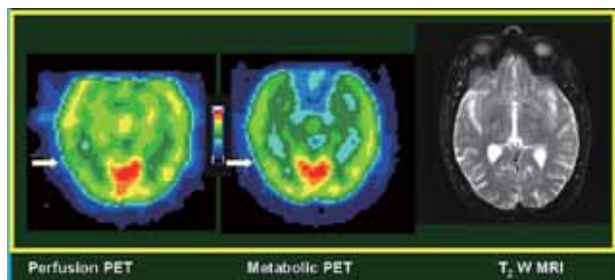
A patient with close head injury and loss of consciousness and with normal MRI had however abnormalities (arrow) in both perfusion and metabolic PET (one color interval = one standard deviation with mean in the center of the scale).
